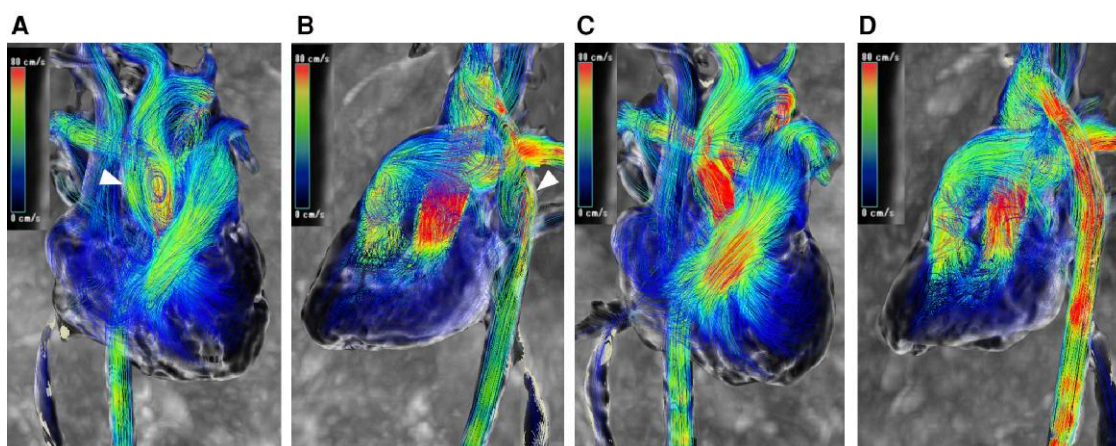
Streamline of four-dimensional flow magnetic resonance imaging. A helical flow (arrow head) is visible in the ascending aorta in the frontal view (A) and in the descending aorta in the lateral view (B) before balloon angioplasty. After treatment, both flows improved (C and D).
